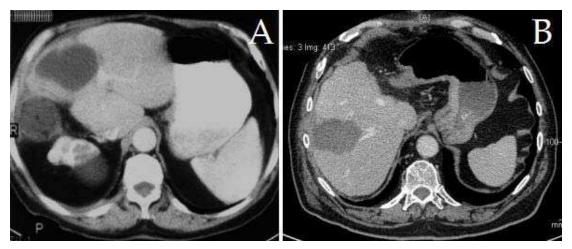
Follow-up computed tomografy of patients after combined RFA and right hepatectomy (A) or left hepatectomy (B) for colorectal liver metastases.
